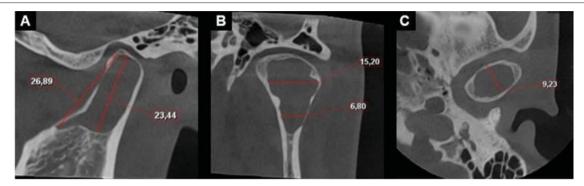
Initial CBCT of the left temporomandibular joint (TMJ) (T1). A: Oblique sagittal section of the mandibular condyle, showing extension of the lesion in a cranio-caudal direction. Involvement of the uppermost area of the mandibular ramus is observed. B: Oblique coronal section of the mandibular condyle with measurements of the lesion in a medio-lateral direction. C: Axial section of the mandibular condyle with measurements of the lesion in an antero-posterior direction.
